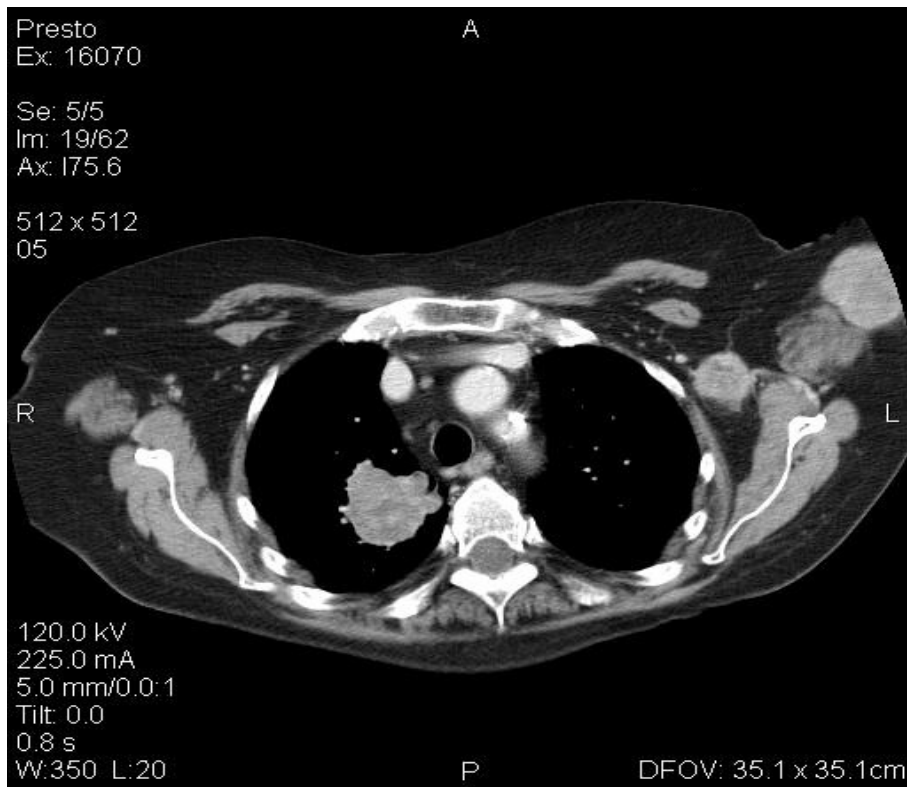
Postcontrast CT, axial section, pulmonary tissue mass, right apical segment, non-homogeneous, 40/38 mm diameter
